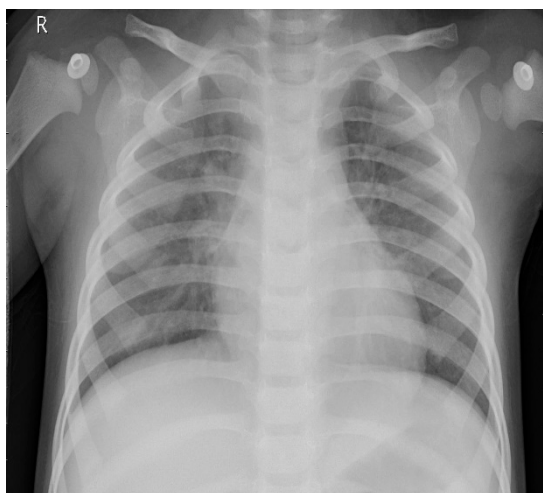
X-ray image of a bacterial pneumonia patient.
